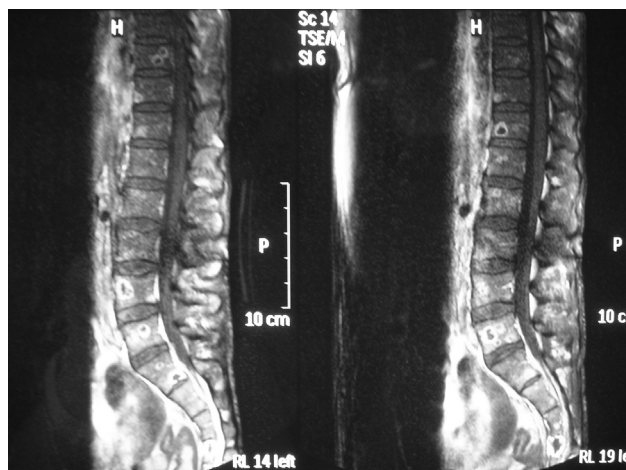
Multiple nodular lesions (tuberculomas) in the vertebral corpus in spinal MRI.
